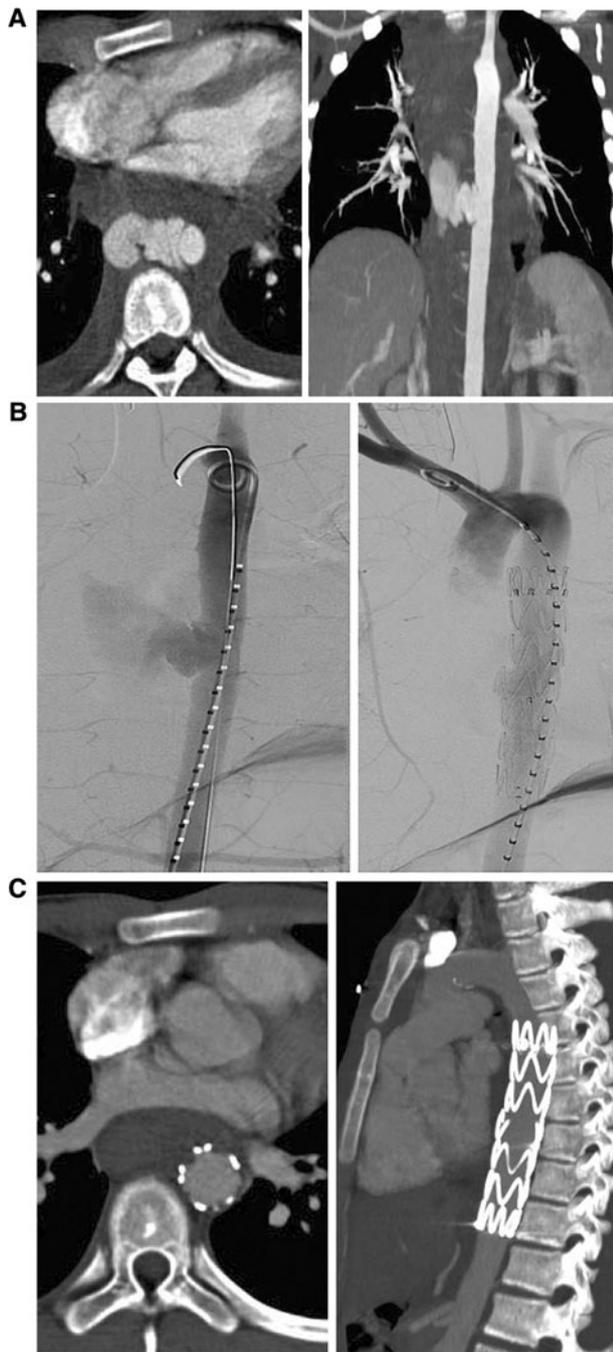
Aortic injury with associated pseudoaneurysm. A-1 Transverse contrast-enhanced multi-detector CT scan reveals an aortic injury (pseudoaneurysm), distant from the left subclavian artery with associated mediastinal hemorrhage adjacent to the medial wall of descending thoracic aorta, highlighted in the three-dimensional reconstruction (A-2). B-1 Initial pre-deployment angiogram revealing active bleeding with contrast extravasation from the site of injury. B-2 Control angiogram after stent-graft deployment showing adequate sealing of the bleeding site. Endograft Repair was successful and the patient survived the injury. C-1 Axial view of the postoperative scan shows a patent endograft with complete resolution of the pseudoaneurysm, with a three-dimensional reconstruction. C-2 Also we can note complete resolution of the mediastinal hemorrhage and pleural collection
